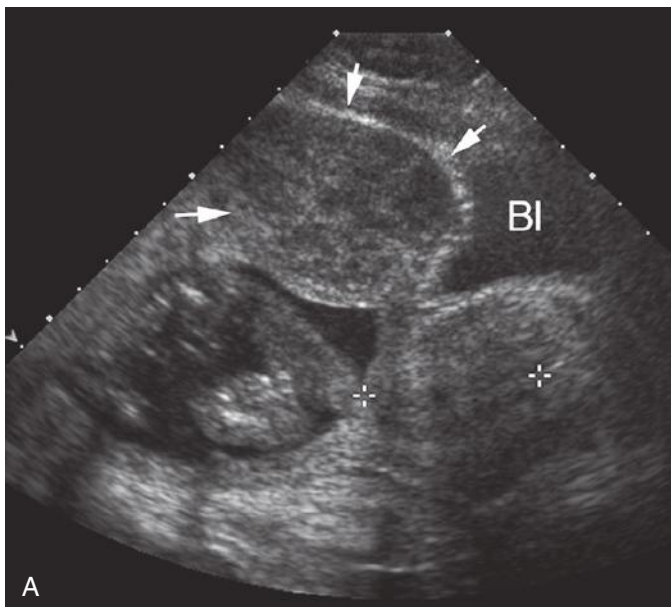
A, Longitudinal sonogram in a pregnant patient at 18 weeks' gestational age. An anterior lower uterine segment leiomyoma (*arrows*) is seen. It does not obstruct the cervix (demarcated by *calipers*). Bl, bladder. B, Well-circumscribed, heterogeneous leiomyomas (*arrows*) in the anterior wall of the uterus in another pregnant patient.
